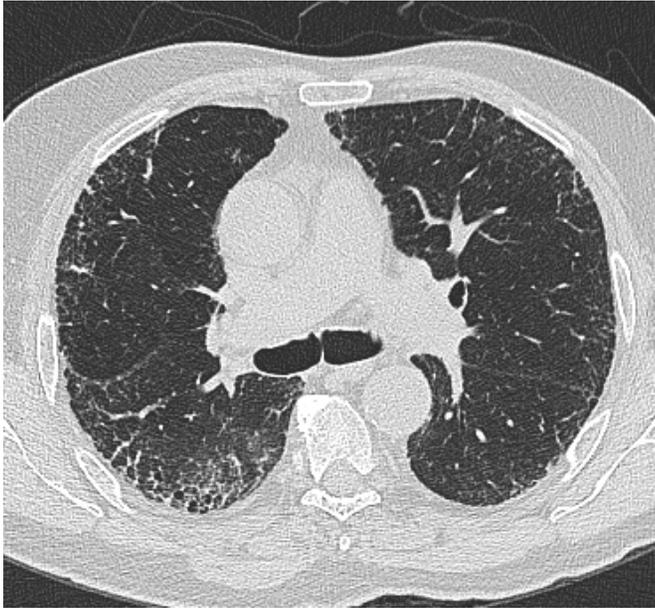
Upper zone: HRCT above the level of carina
